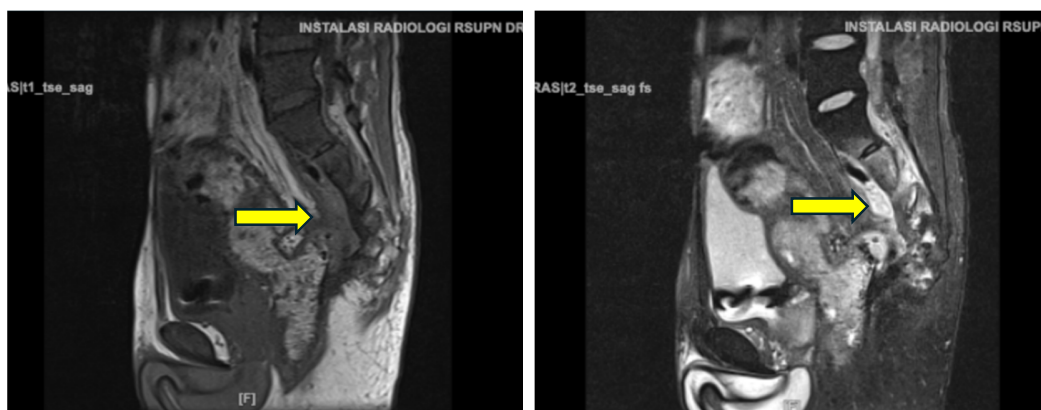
MRI abdomen with contrast showing visible contrast thickening and fibrosis accompanied by foci of air obliterating the presacral fat space measuring approximately 1.5 x 5.5 x 5.1 cm (arrow).
